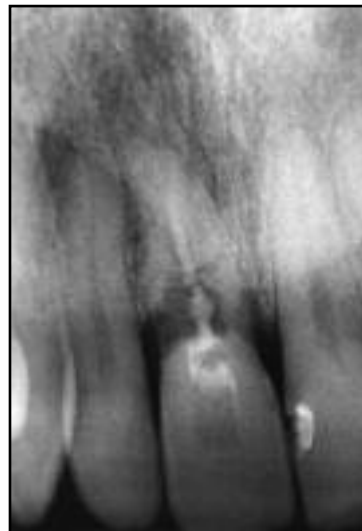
(right) Pretreatment radiograph of the maxillary right central incisor. Note the clearly defined granuloma.
